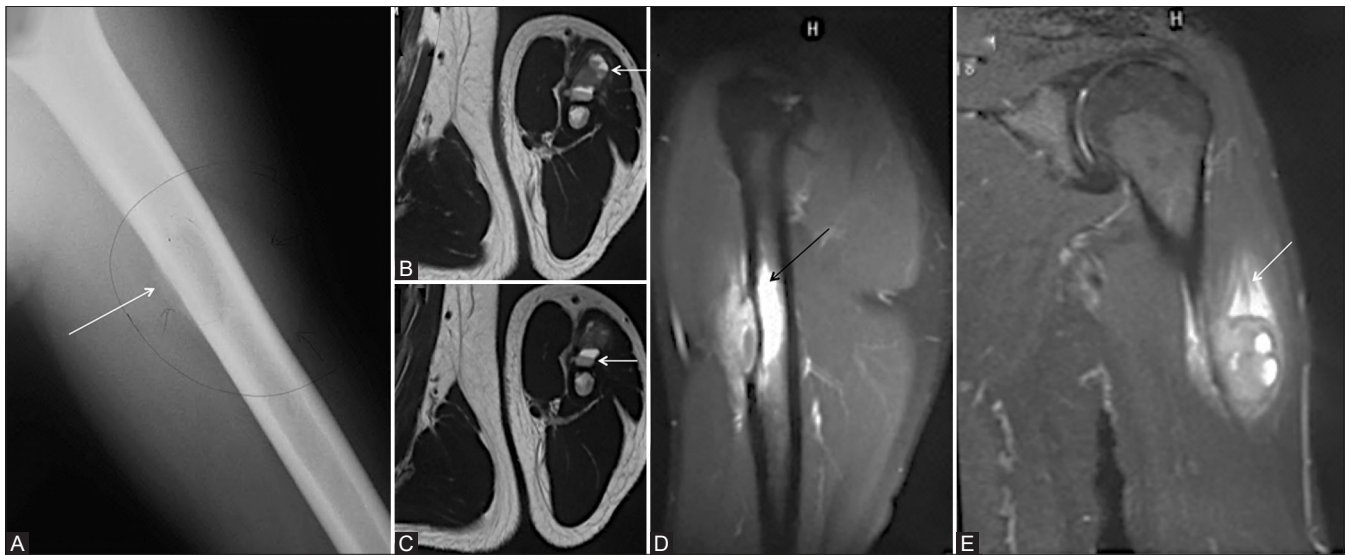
(A-E): A 30-year-old female with swelling in the left arm. AP radiograph of the left arm shows expansile, eccentric lytic lesion in mid-diaphysis of the left humerus (arrow, A). (B-E) Axial T2W, Sagittal T2W fat-saturated, and Coronal T2W fat saturated MR images showing large exophytic soft tissue component with blood-fluid levels (arrow, B and C) with extensive marrow (arrow, D) and soft tissue oedema (arrow, E)
